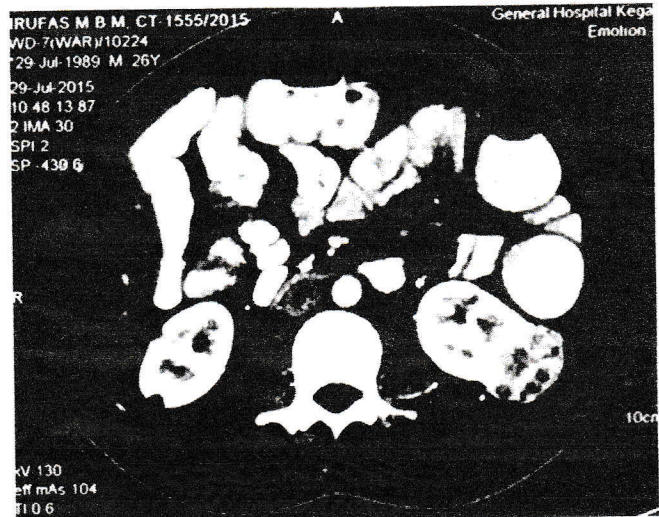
Contrast enhanced CT scan of the abdomen showing bilateral renal tumors.
